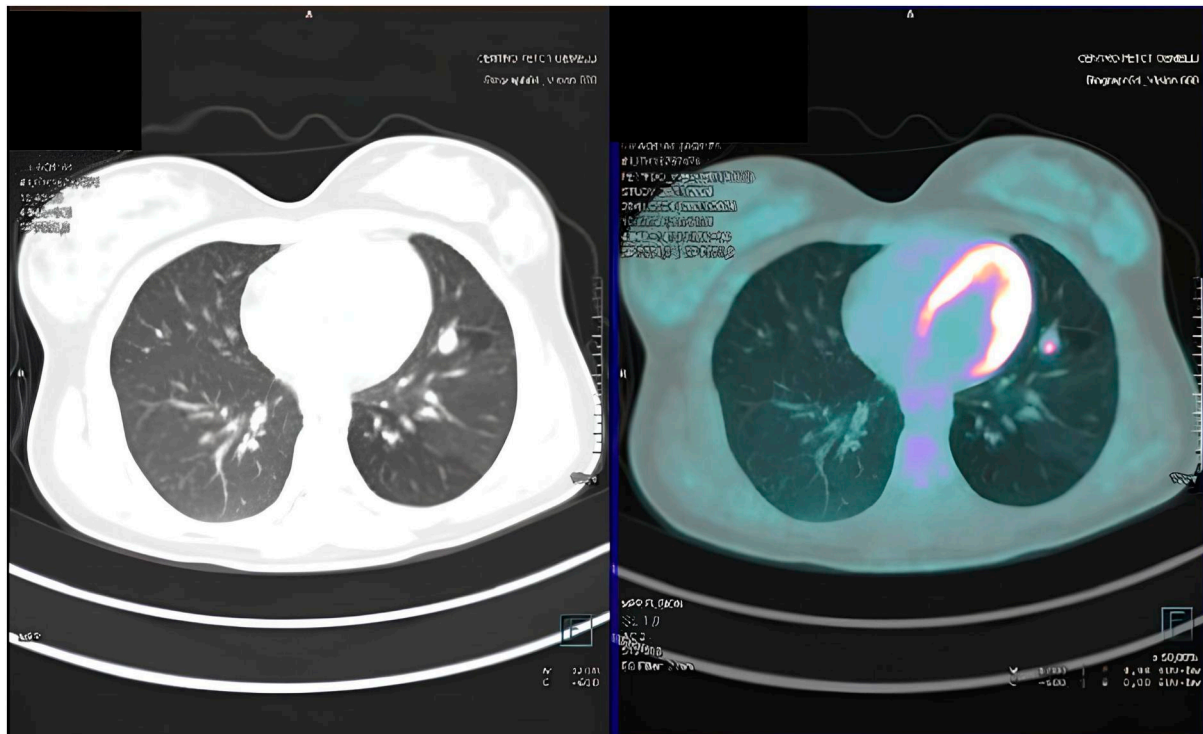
CT scan revealed a 13×9 mm peri-fissural nodular lesion in the lingular segment of the left lung, along with a 12×7 mm left hilar lymph node. PET showed increased metabolic activity in both the lingular nodule (SUVmax 4.6) and the left hilar lymph node.
